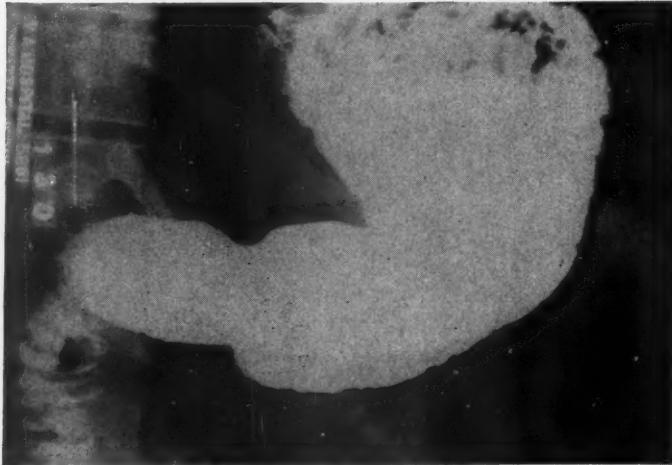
Roentgenogram of a 28 year old man recently admitted to the Veterans Hospital of Seattle for evaluation of recurrent bouts of "indigestion." Careful examination of the duodenum revealed only the filling defect visualized above on the lesser curvature of the second portion. The patient elected to postpone exploration. This may be a myoepithelial hamartoma. It certainly merits exploration.
